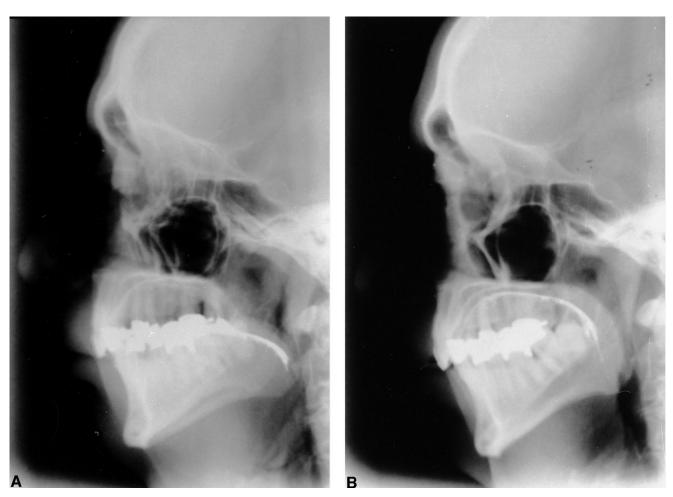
Case 2: Lateral cephalograms. (A) Initial x-ray. (B) Follow-up x-ray after 2.4 years of MAA-treatment with the MAA.
